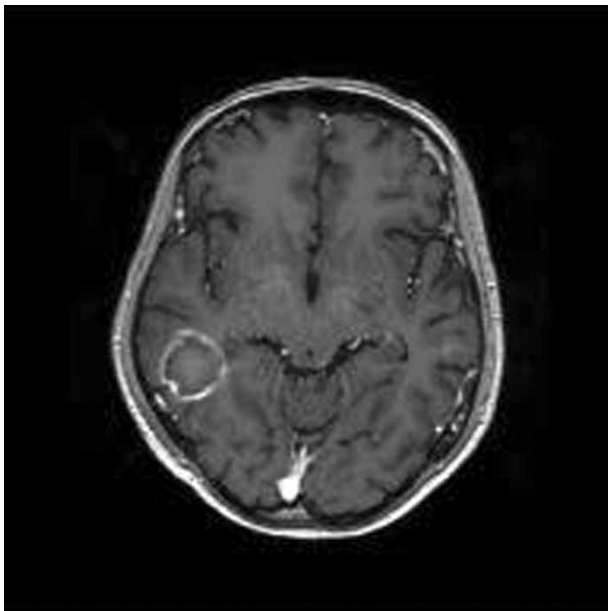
Gadolinium-enhanced axial T1 magnetic resonance imaging of the head showing a ring-enhancing mass in the right posterior lobe of the renal transplant patient.
